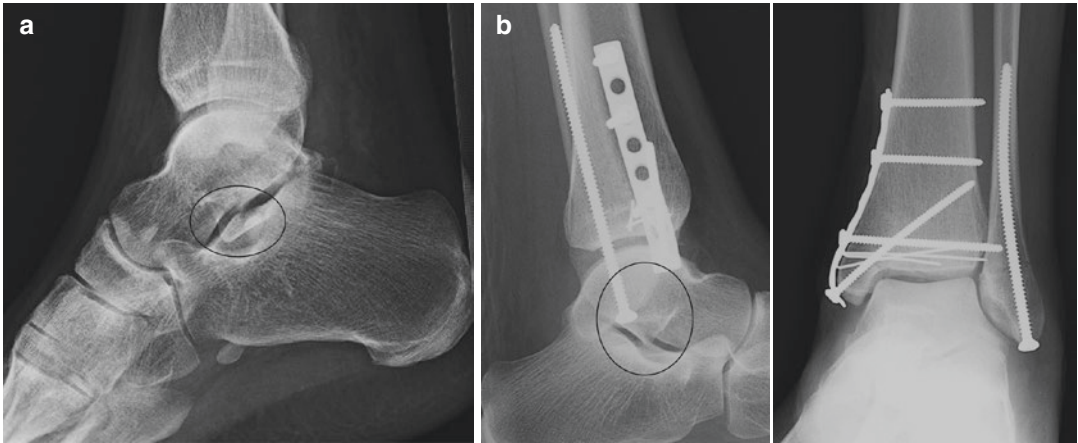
(a) Lateral radiograph of the ankle demonstrating a double density, suggestive of a lateral process fracture. Routinely the lateral process is displaced distally
